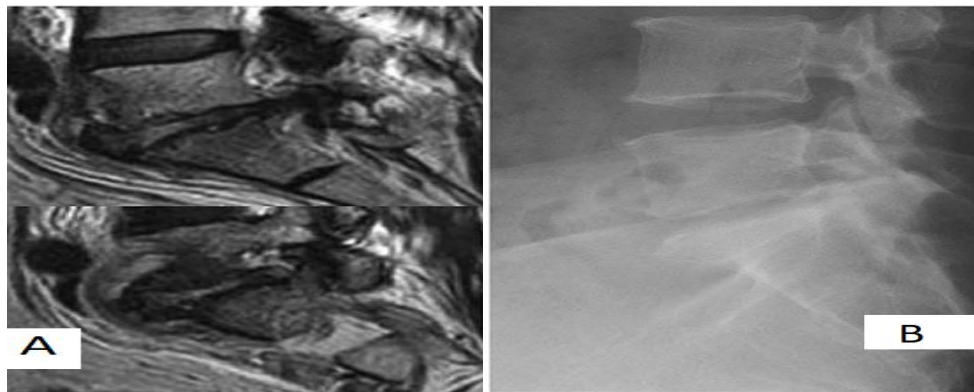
Preoperative A: MRI, B: X-ray of female patient 56 years old with L5-S1 Spondylodiscitis. Her VAS score on admission was 7. Frankle scale was C preoperatively. And ODI was 84%.
